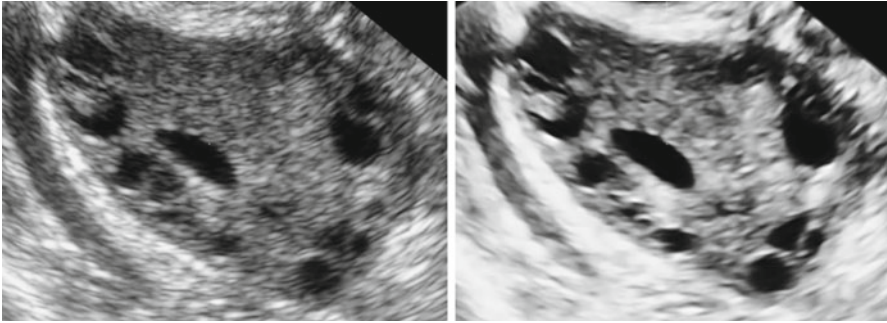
Effect of the volume contrast imaging (VCI) on image quality when using 3D ultrasound: same ovary without (*left*) and with VCI (*right*)
